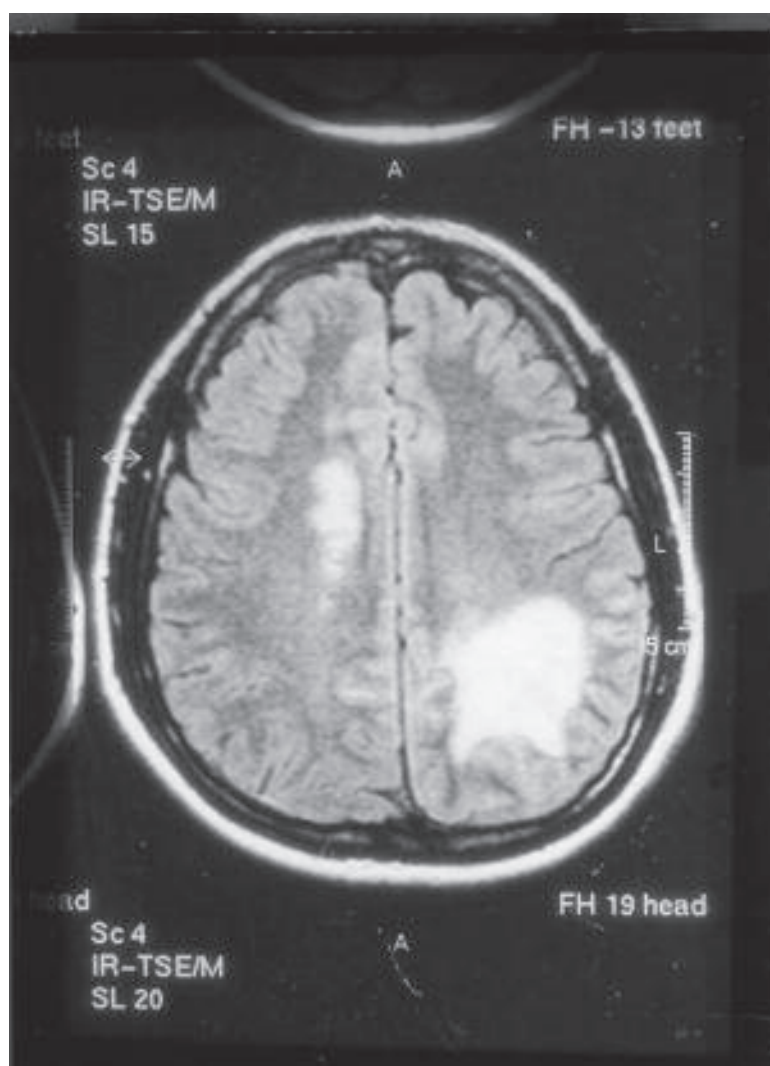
Axial T2 weighted FLAIR MRI of the brain showing hyperintense white matter lesions in the left parietal and right semi-centrum ovale.
